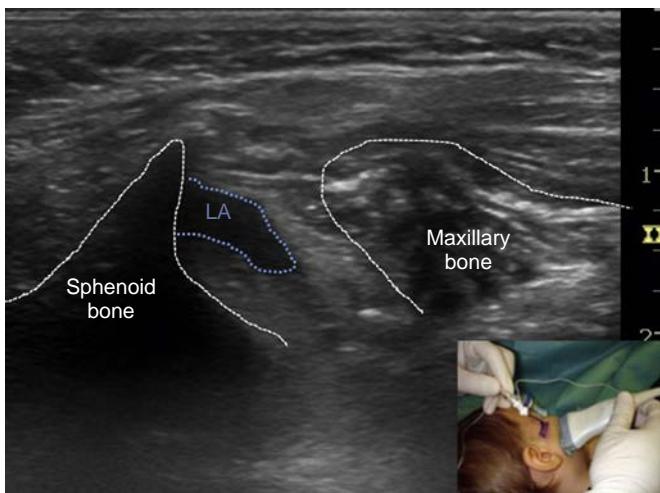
Ultrasound imaging of suprazygomatic maxillary nerve block with local anesthetic (LA) injection.
